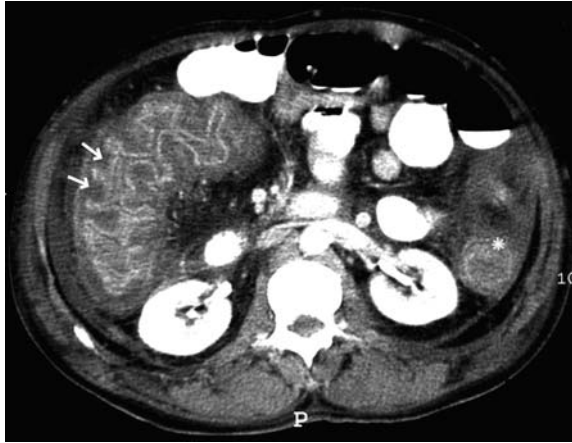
Abdominal computed tomography section showing a severely thickened and edematous right (white arrows) and left (asterisk) colonic mucosa
